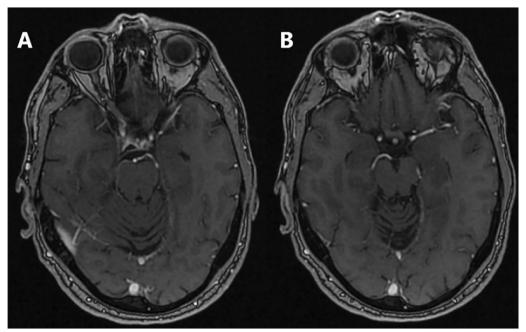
Axial three-dimensional T1-weighted magnetic resonance imaging sequences after intravenous contrast administration. A No residual enhancement in the pons, indicating complete resolution of previously observed lesions. B Absence of contrast enhancement in the midbrain, confirming radiological resolution. Compare with Fig. 5
